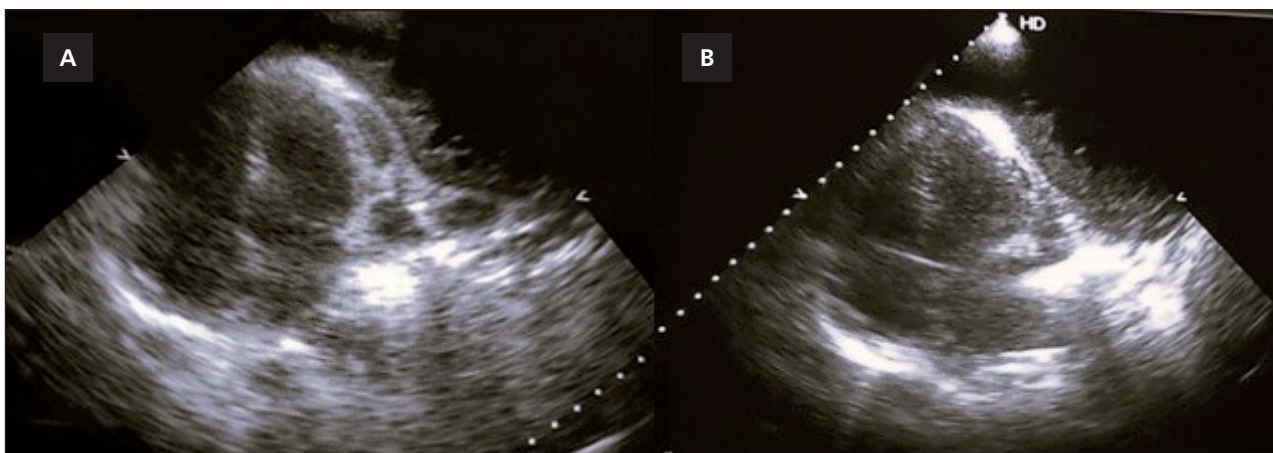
Bedside echocardiogram 4-chamber view (A and B): large loculated pleural effusion adjacent to the pericardium with thickening and hyperechogenicity of the pleura and pericardium.
